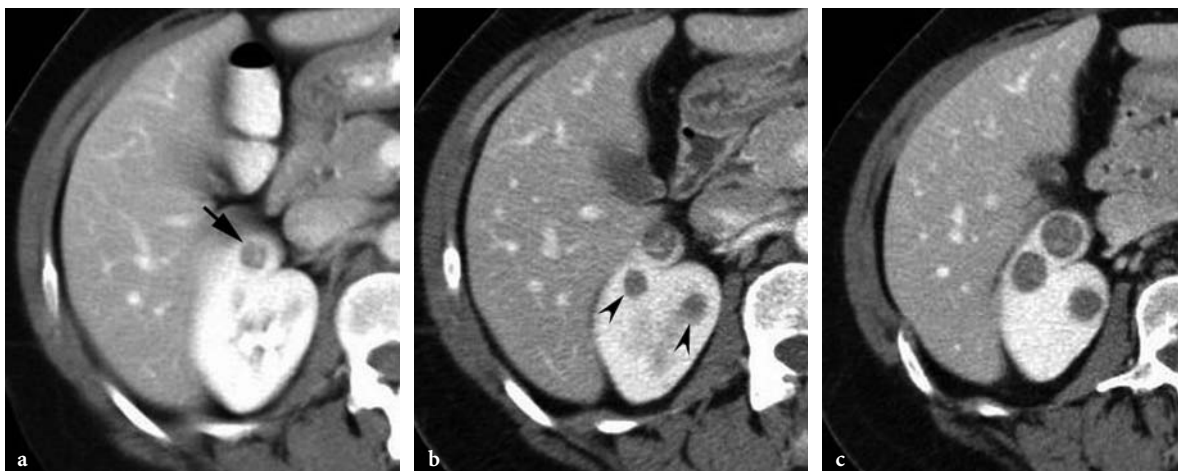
Growth of RCC in a 55-year-old woman post-left nephrectomy for clear cell carcinoma. No history of hereditary or familial renal cancer syndromes. a Axial contrast-enhanced CT scan shows 7 mm tumor in the anterior right kidney (*arrow*). b Axial contrast-enhanced CT scan 2 years later shows that the lesion grew to 12 mm in diameter and two smaller lesions appeared (*arrowheads*). c Axial contrast-enhanced CT scan 4 years after the first scan (a) shows that the anterior mass increased to 18 mm diameter. The resected lesions were all clear cell carcinoma. Additional masses were treated with radiofrequency ablation.
